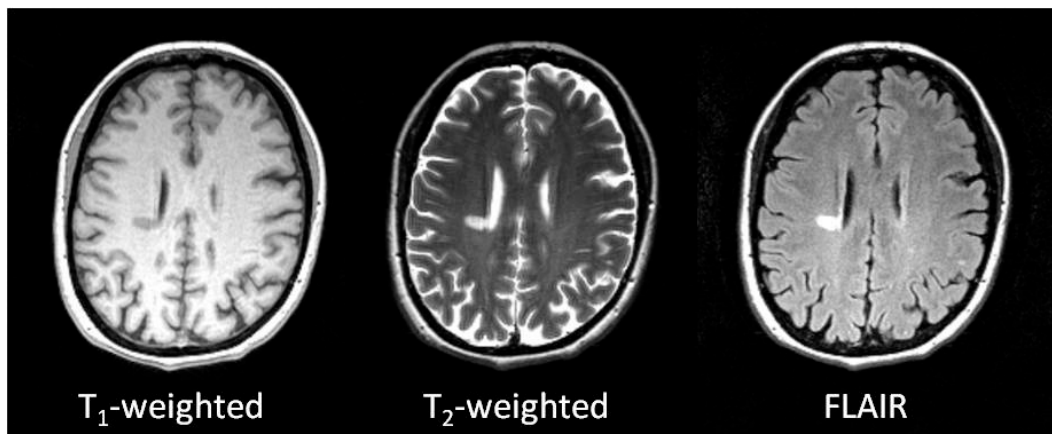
A T<sub>1</sub>-hypointense lesion seen in the image above is also called a 'black hole'. However, black hole lesions appear hyperintense on both T<sub>2</sub>-weighted and fluid attenuated inversion recovery (FLAIR) images.
